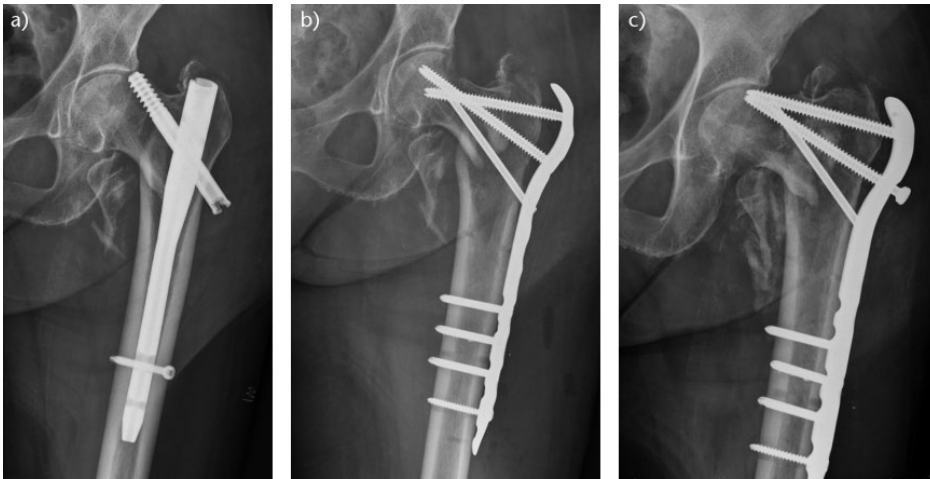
Radiographs showing Cut out of femoral fixation: a) classic posterosuperior screw cut-out; b) revision fixation with fixed angle device. No compression of the fracture site is possible with proximal femoral plate systems and c) Secondary failure of fixed angle proximal femoral plate system.
